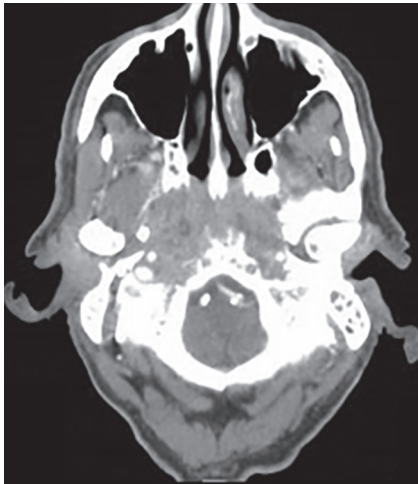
Computerized tomography (CT) scan showing infiltrative lesion of the nasopharynx with ill-defined limits and erosions from the adjacent region of the skull base
